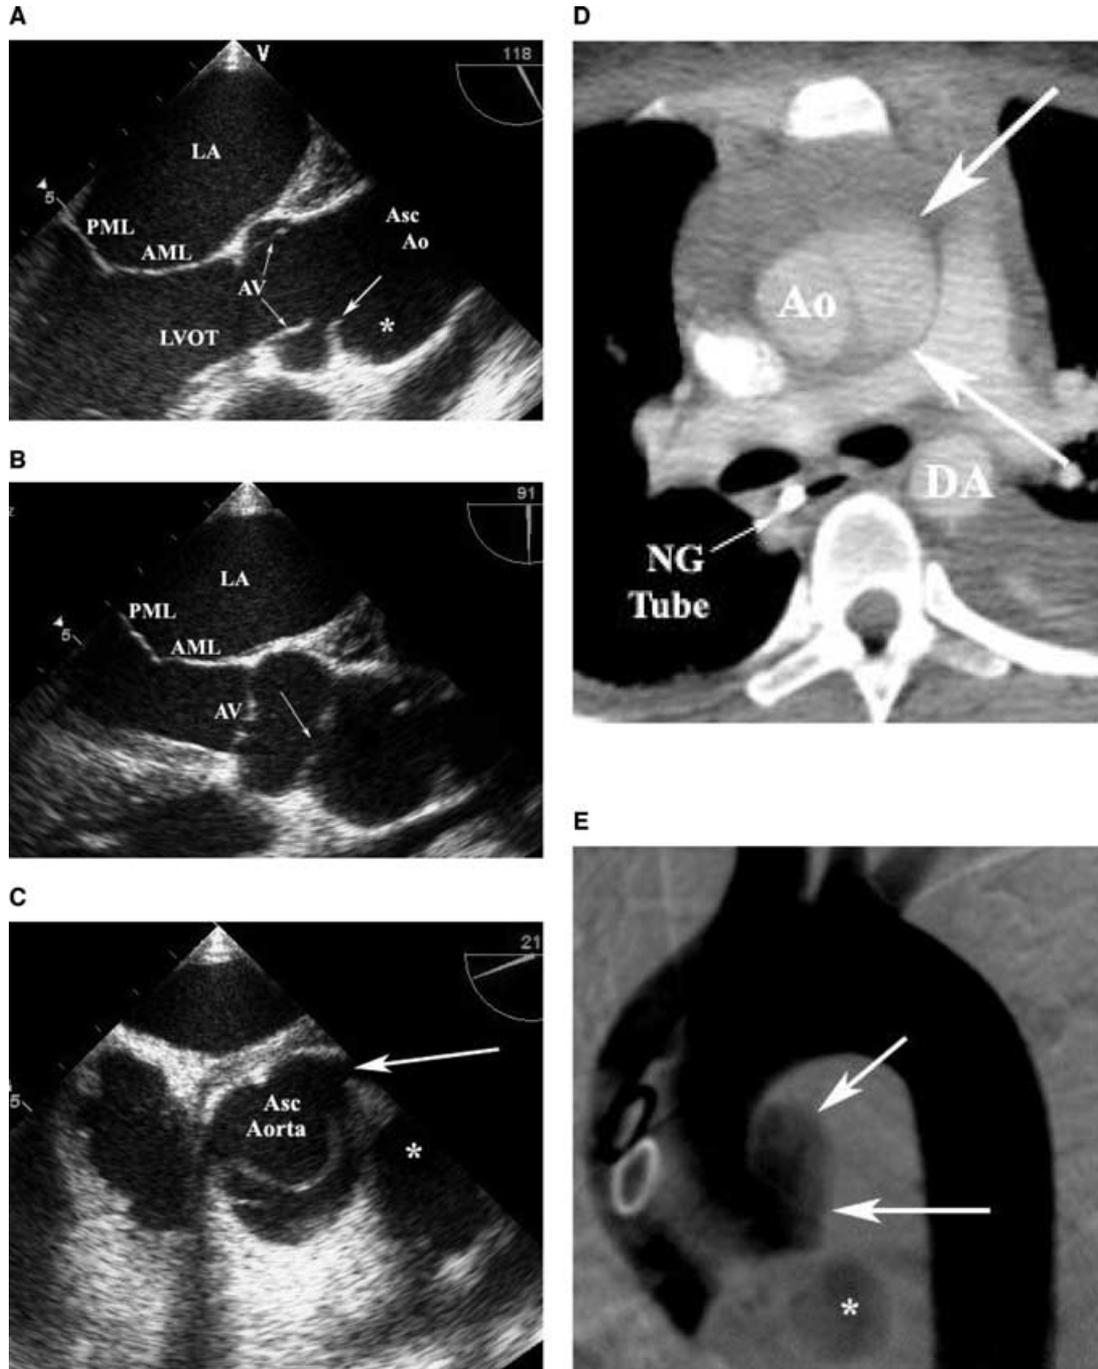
During a high speed chase, an unrestrained 25-year-old female was thrown from a motor vehicle as it flipped over. Multiple orthopedic injuries were noted upon arrival to the trauma room. TEE was initially performed. A moderate-sized pericardial effusion was initially noted. The aortic isthmus was unremarkable, but the ascending aorta appeared abnormal. A. Imaging at 118° revealed an abnormal contour (*) of the ascending aorta (Asc Ao), above the level of the aortic valve (AV) and sinus of Valsalva. A tear (arrow) is seen at the level of the sinotubular junction. B. Changing the transducer to a vertical imaging angle (91°) and C. transverse plane through the aorta (21°) revealed a localized “tear” across the aorta at the level of the sinotubular junction. A possible adventitial pseudoaneurysm (*) with its mouth located just anterior and superior to the left main coronary artery (arrow) was considered. D. Computed tomography revealed the pseudoaneurysm (arrows) adjacent to the proximal ascending aorta (Ao). The descending aorta (DA), and a nasogastric tube (NG Tube) within the esophagus are also noted. E. Digital subtraction angiography of the thoracic aorta from a right anterior oblique projection confirmed the presence of a pseudoaneurysm (arrows) and also aortic regurgitation (*).
